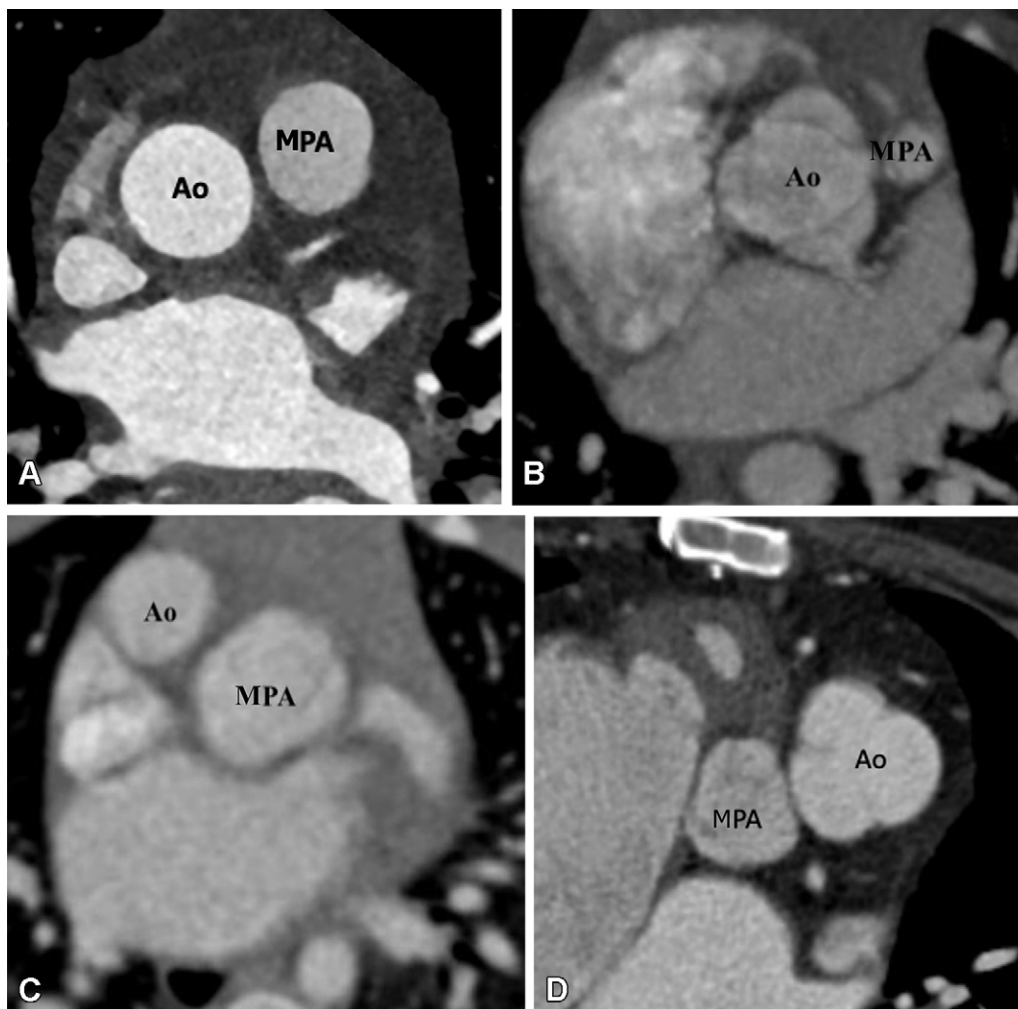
Great vessels relationship. (A) Normal great vessels relationship in a 25-year-old healthy man. Axial contrast-enhanced CT image shows the ascending aorta is in a position posterior and to the right of the pulmonary artery. (B) Normal relationship in a 2-year-old boy with TOF-type DORV. Axial maximum intensity projection (MIP) CT image shows the ascending aorta in a position posterior and to the right of the pulmonary artery. Pulmonary stenosis is observed, which is a common feature of TOF-type DORV. (C) Dextrotransposition in a 1.5-year-old girl with TGA-type DORV. Axial MIP CT image shows the ascending aorta in a position anterior and to the right of the MPA. (D) Levotransposition in a 2-year-old girl with TGA-type DORV. Axial MIP CT image shows the ascending aorta in a position anterior and to the left of the pulmonary artery. Ao = aorta, DORV = double-outlet right ventricle, MPA = main pulmonary artery, TGA = transposition of the great arteries, TOF = tetralogy of Fallot.
